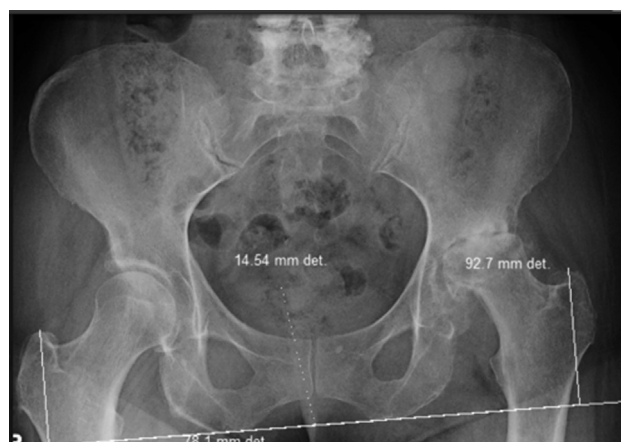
Preoperative anteroposterior pelvis radiograph of case 2 with evidence of femoral head collapse and severe osteoarthritis consistent with Paprosky 2B defect.
